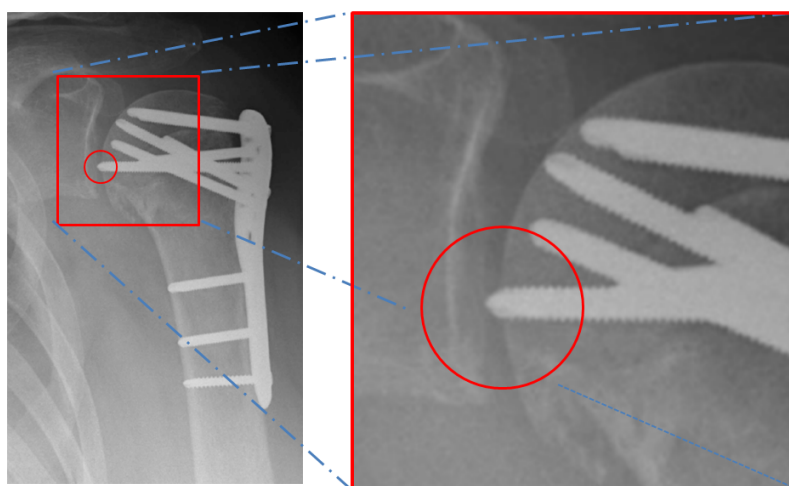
X-ray image depicting one fixation screw perforating the shoulder joint surface.
